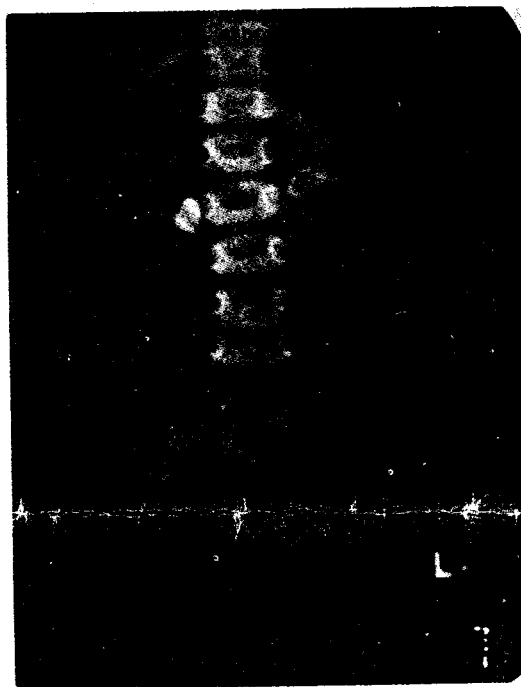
X-ray KUB showing bilateral renal stone
